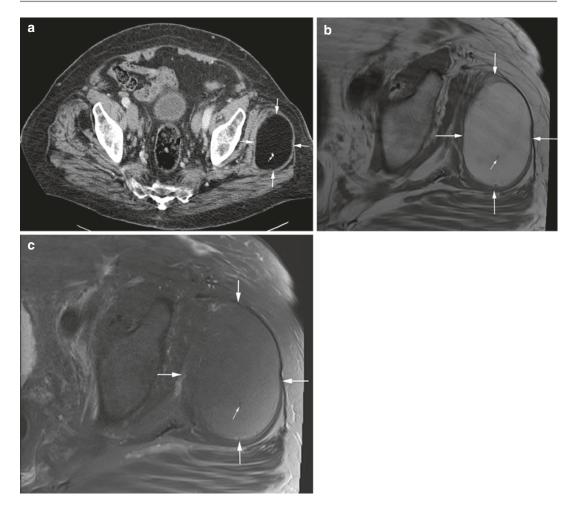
(a–c) Intramuscular lipoma of the left gluteus medius thigh. (a) CT scan. (b) Axial SE-T1-weighted MR image. (c) Axial TSE T2-weighted fat-suppressed MR image. Large mass in gluteus medius muscle (*arrows*) of the left thigh with low attenuation values on CT (a). The
